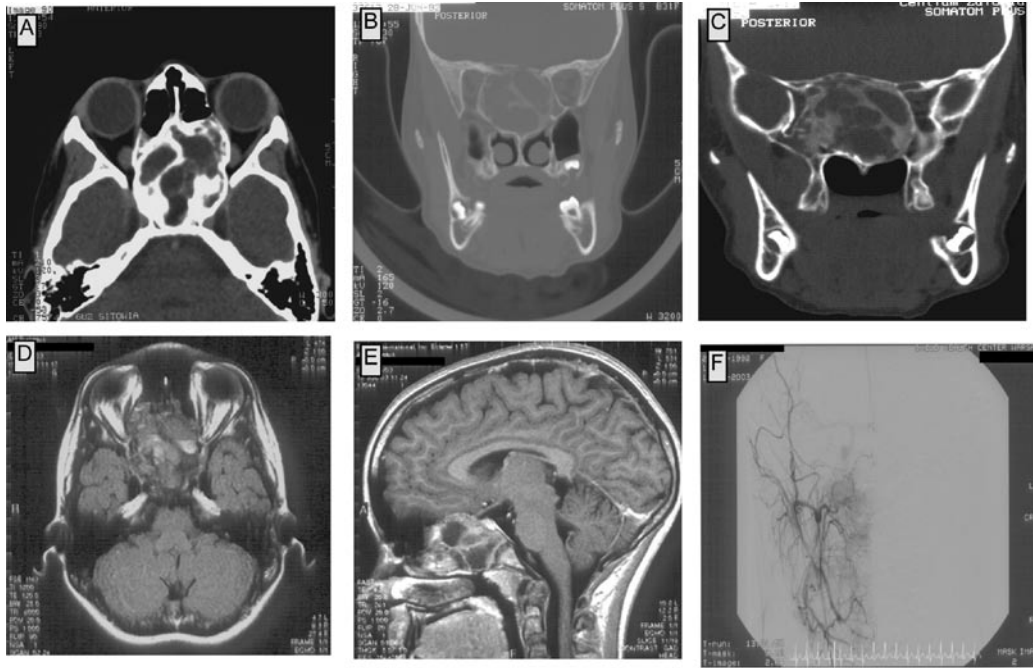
Computed tomography and magnetic resonance imaging scans showing the primary tumor. CT scans showing a tumor filling the upper-posterior region of the nasal cavity, the posterior ethmoids and the sphenoid sinuses and orbits modelled by the tumor (A and B). Numerous bony trabeculae and areas of calcification are shown (C). No contrast enhancement in the tumor is observed in the MRI scans (D). MRI scans showing a tumor with an approximate diameter of 55x35x55 mm, involving the corpus of the sphenoid bone, the ethmoids bilaterally and the upper part of the nasal cavity. In the frontal and temporal region, the lesion invades the cranial base, while no signs of brain infiltration are found (E). Pre-operative angiography scans show very poor vascularization of the tumor with tumor vessels originating from the right facial artery and tumor blood supply from the left internal carotid artery (F).
